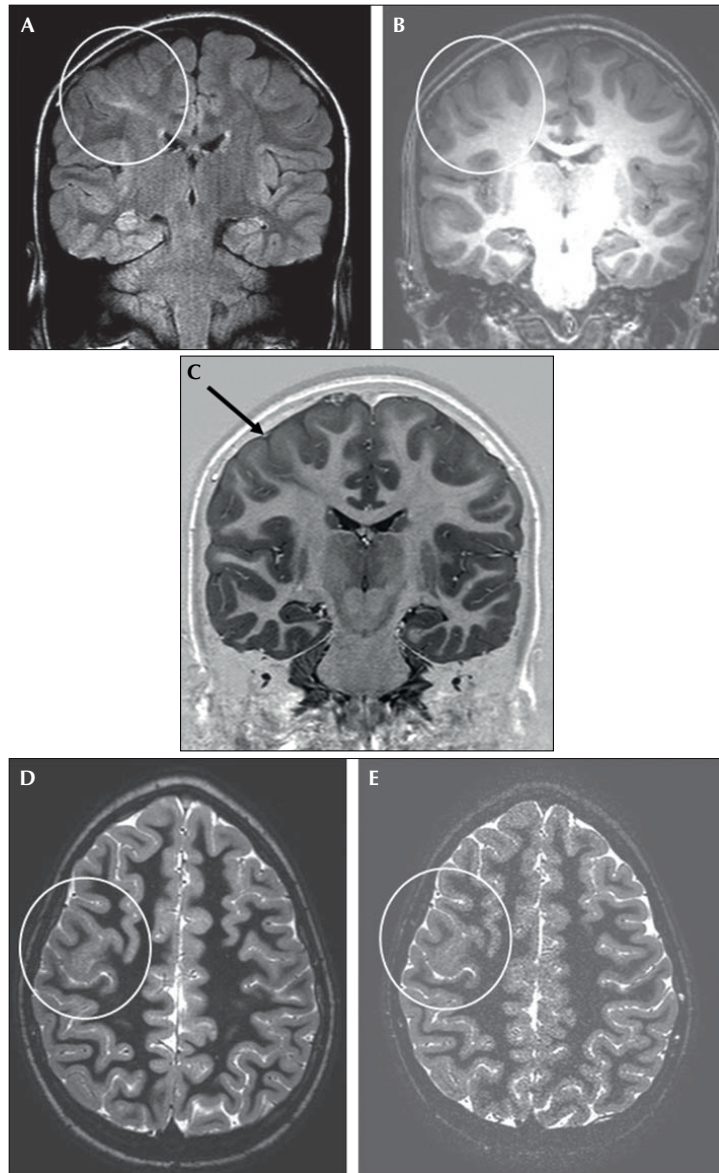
13-year-old girl with right frontal lobe epilepsy (pat # 13 in *table 1*) and focal transmantle cortical dysplasia on MRI. A) 3T, coronal, T2-w FLAIR sequence shows right-sided, subcortical, hyperintensity extending radially towards the lateral ventricle (white circle). B) 3T, coronal, T1-w 3D GRE sequence confirms cortical abnormality (white circle) in the same region. C) 3T, head coil, coronal T1-w IR real image better depicts the cortical thickening and blurring of the cortical-white matter junction (arrow). Tissue with grey matter signal extends radially towards the lateral ventricle. D) Axial head coil, T1-w IR modulus image confirms the cortical thickening and blurring on the right side (white circle). E) The corresponding surface coil, T1-w, modulus image provides a few more details, but is noisier. Decreasing signal-to-noise ratio and thereby image quality with increasing distance from the surface coils.
